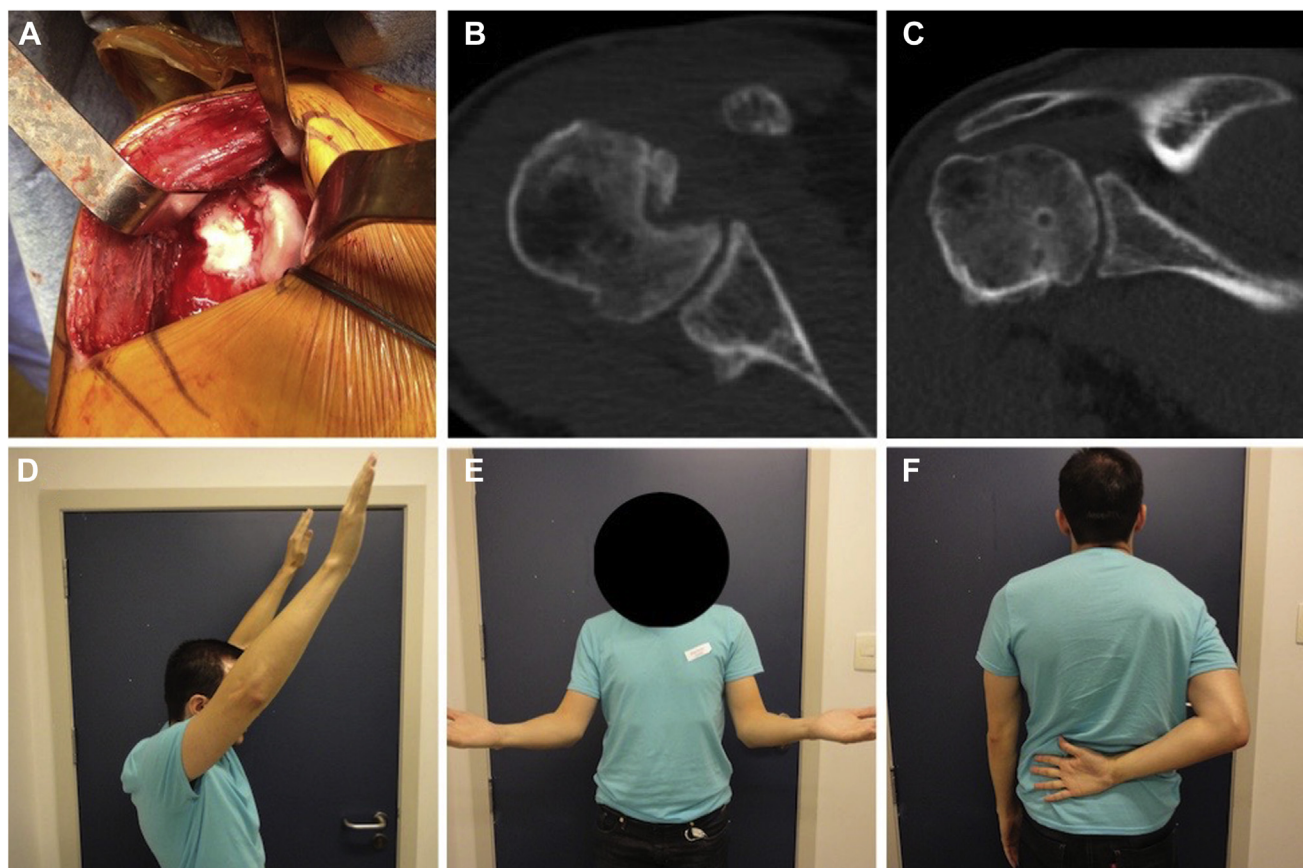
(A) Intraoperative photograph after humeral reduction showing a large reverse Hill-Sachs lesion of the right shoulder. (B, C) Immediate postoperative computed tomography scans showing the results of the modified McLaughlin procedure. (D-F) Good functional results of the right shoulder were observed 2 years after surgery.
